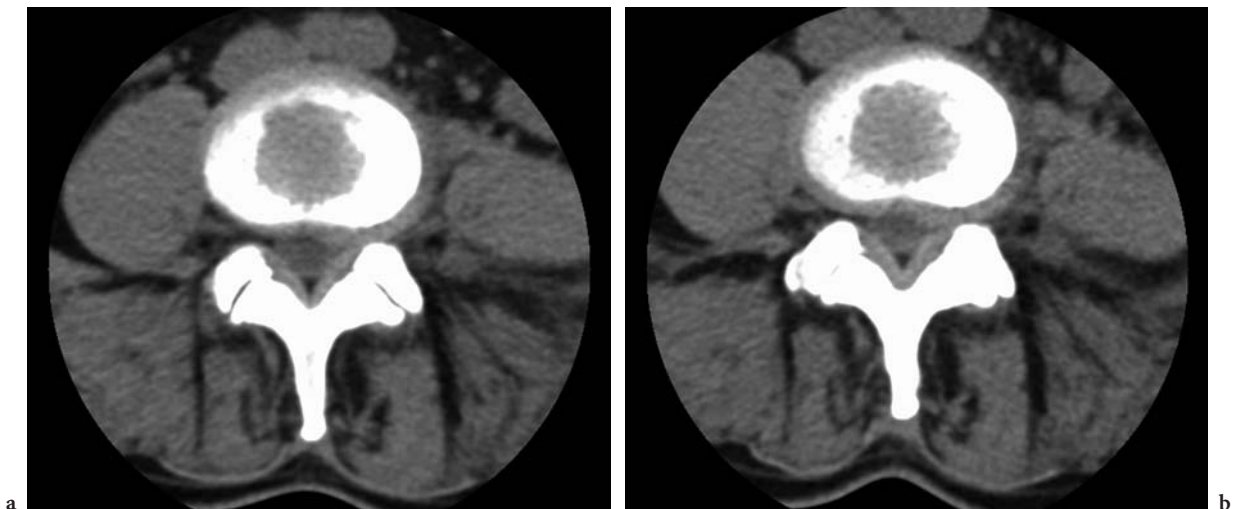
Disc bulging supine-unloaded and during loading. a Bulging disc on supine-unloaded CT. b During AL one can appreciate increased disc bulging (in particular posterolateral on the left and intraforaminal) and thickening of the yellow ligaments. Together these cause a central spinal stenosis
